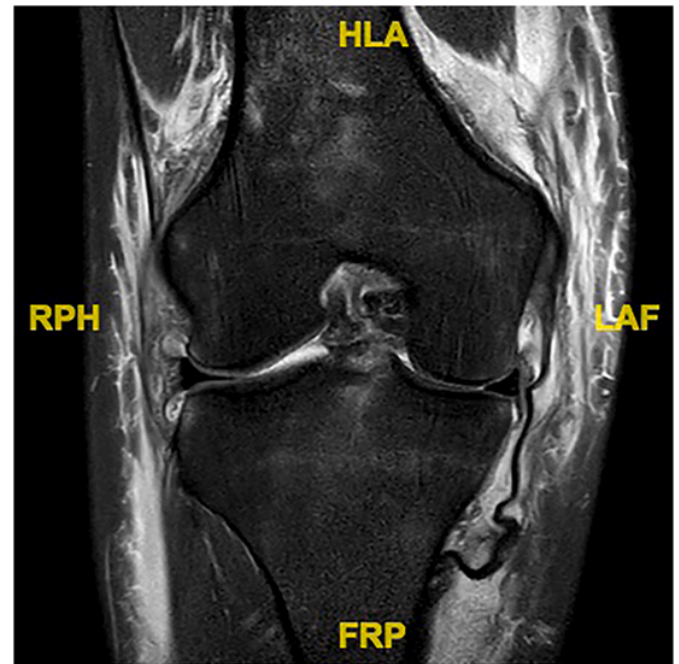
Coronal T2-MRI confirming MCL stenner-like injury.
